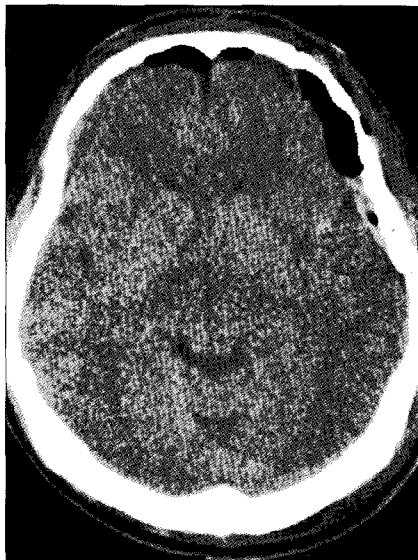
Postoperative brain computed tomographic scans shows unremarkable findings except small amount of pneumocephalus.
